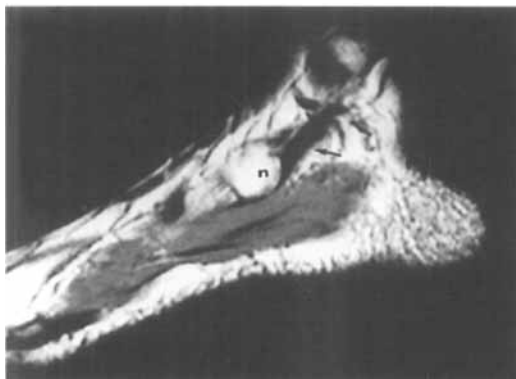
T2-weighted MRI images showing tibialis posterior tendon (arrow) continuity under the accessory navicular. n: navicular bone
